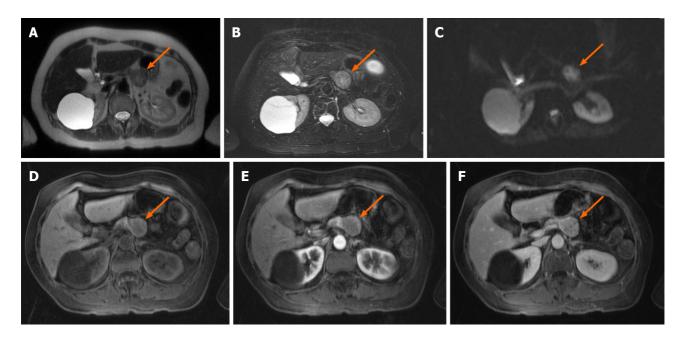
Magnetic resonance imaging scan of the abdomen showing a distal pancreatic mass of 29 mm. A: On the T2-weighted image, the lesion contained mixed signals (orange arrow); B: T2 fat saturation; C: Diffusion-weighted; D: T1-weighted fat sat gadolinium; E and F: T1-weighted image during arterial and portal phase that shows a hypovascular lesion.
